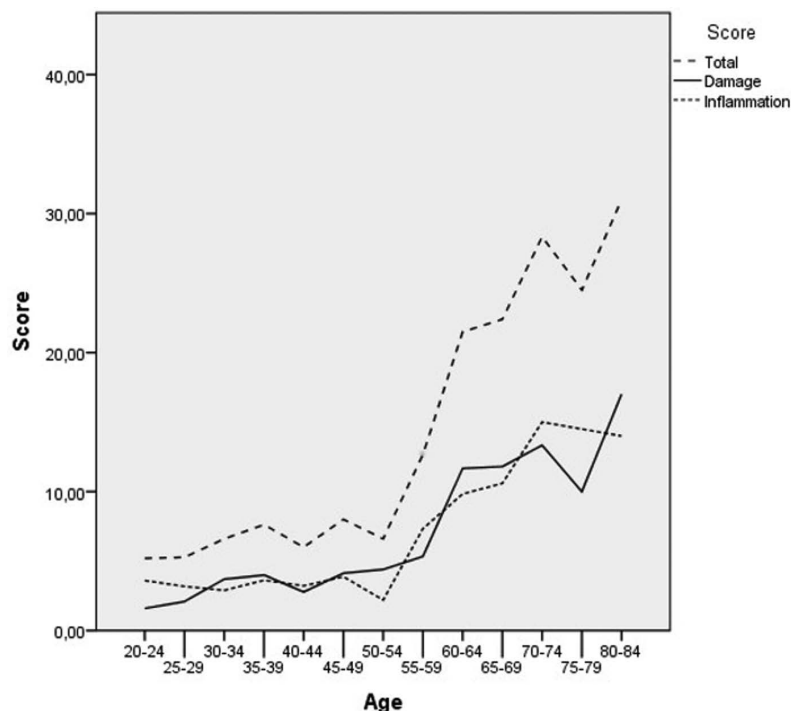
The effect of age on enthesitis scores as revealed by ultrasound.
